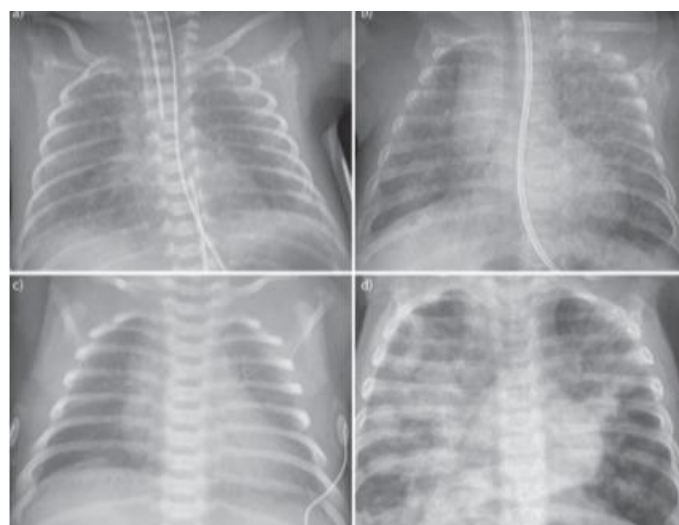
Chest radiograph images ⁽³⁸⁾
